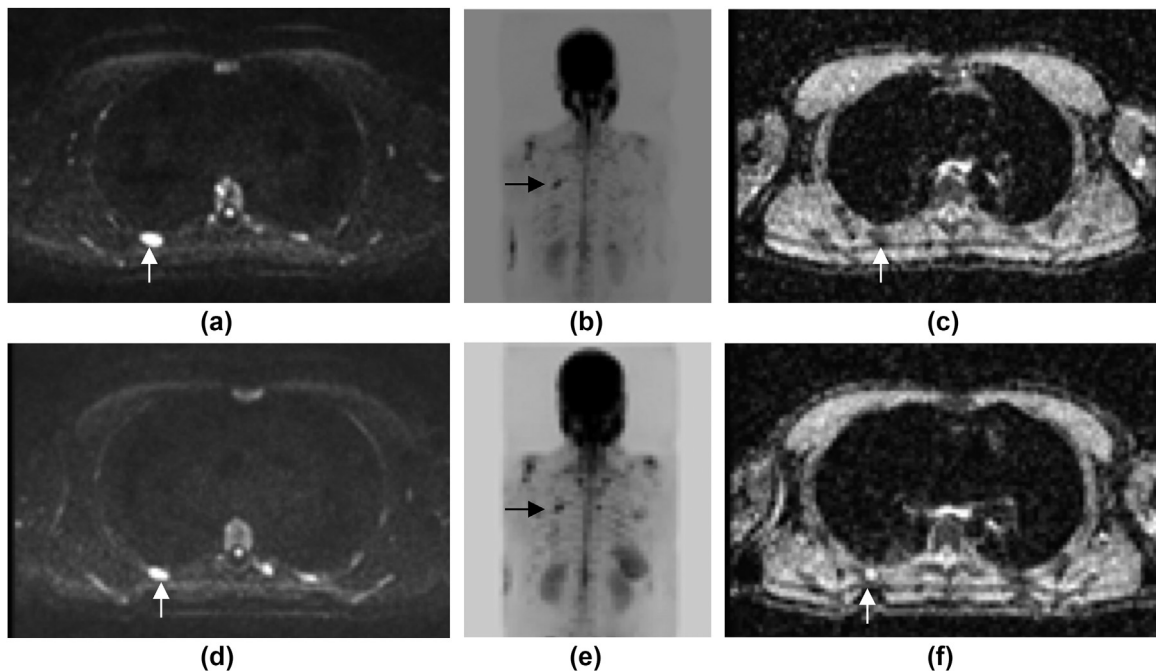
(a–c) Axial $b = 900 \text{ s/mm}^2$ DW-MRI, $b = 900 \text{ s/mm}^2$ MIP, and ADC map pre- and (d–f) post-chemotherapy in a patient with myeloma. The right posterior rib lesion (arrows) appears unchanged following treatment on $b = 900 \text{ s/mm}^2$ and MIP images; however, the ADC map confirms that the lesion showed impeded diffusion at baseline and high ADC following treatment in keeping with response. Post-treatment signal on $b = 900 \text{ s/mm}^2$ images represents T2 shine-through.
